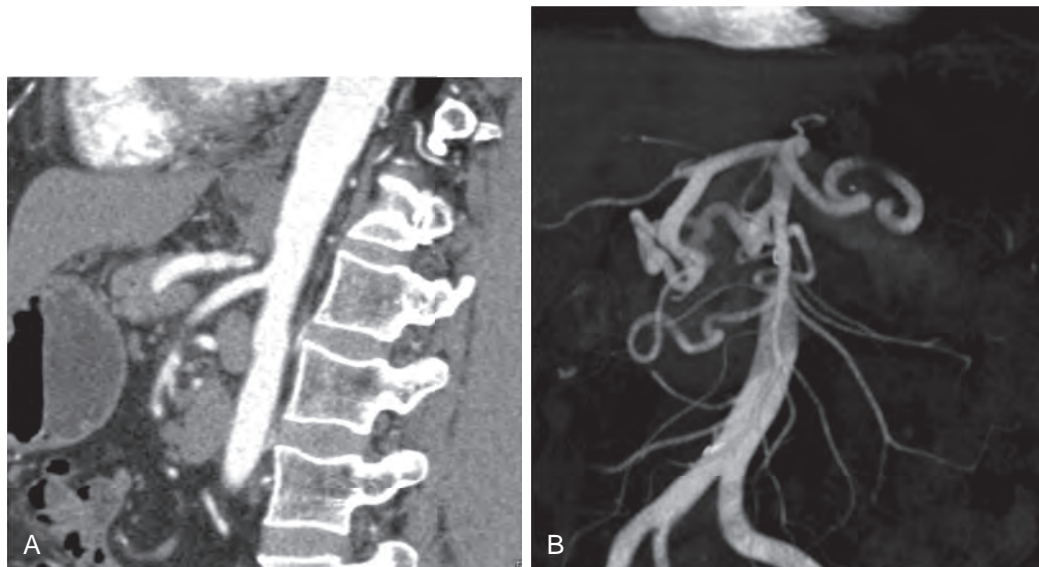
Median arcuate ligament syndrome. A. Sagittal contrast-enhanced image shows severe narrowing of the proximal celiac artery by a prominent median arcuate ligament. B. Coronal CTA with MIP shows enlarged and dilated pancreaticoduodenal collaterals supplying the celiac from the SMA.
